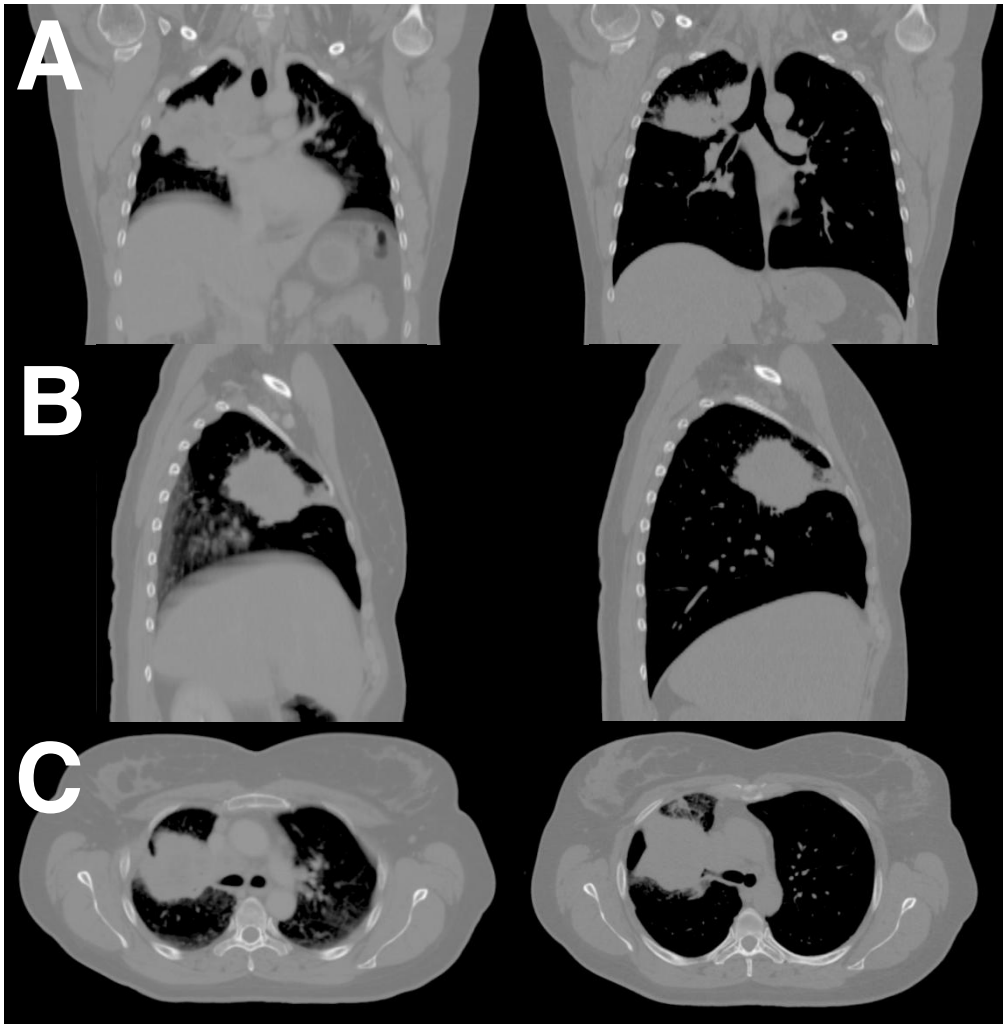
Coronal (A), sagittal (B), and transversal (C) slices of the CT scan for patient number 7. On the left hand side is the FB image set, and on the right hand side is the DIBH image set. For this patient, the total lung volume increased by 167% in DIBH.
